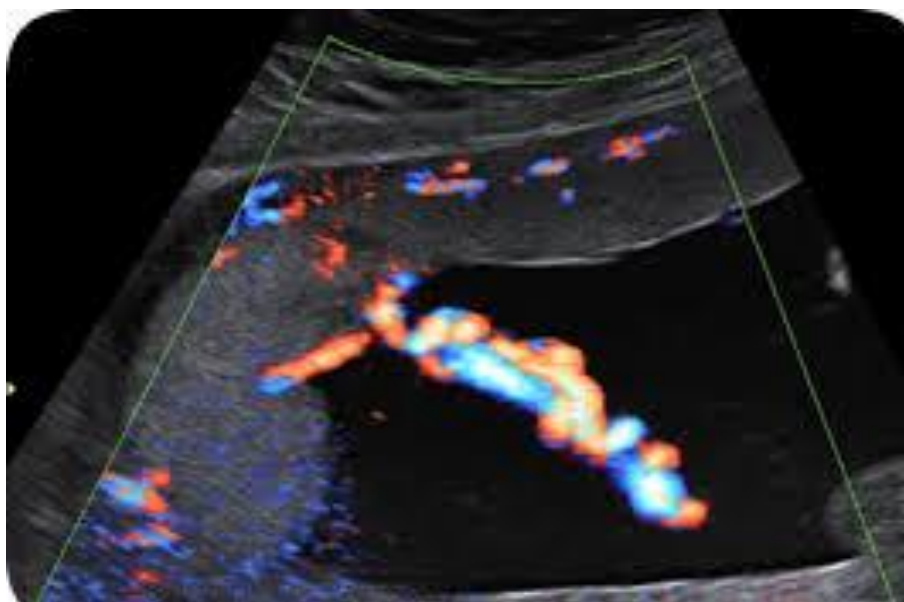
Doppler US of normal PL thickness & umbilical cord (Author source; 2018).
